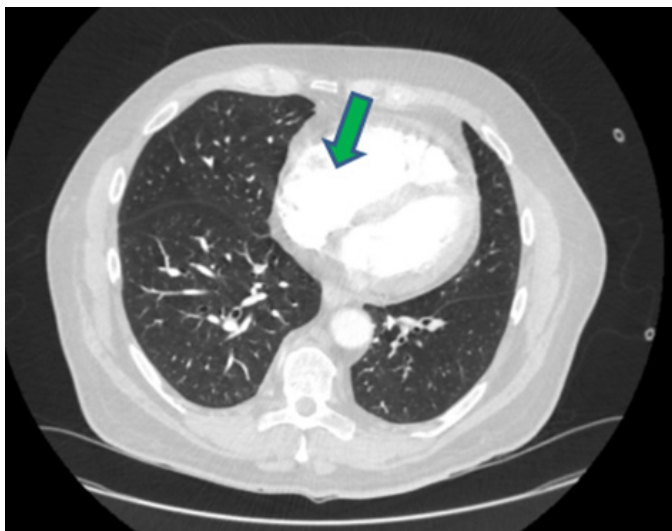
CT pulmonary angiogram green arrow shows right ventricular hypertrophy.
